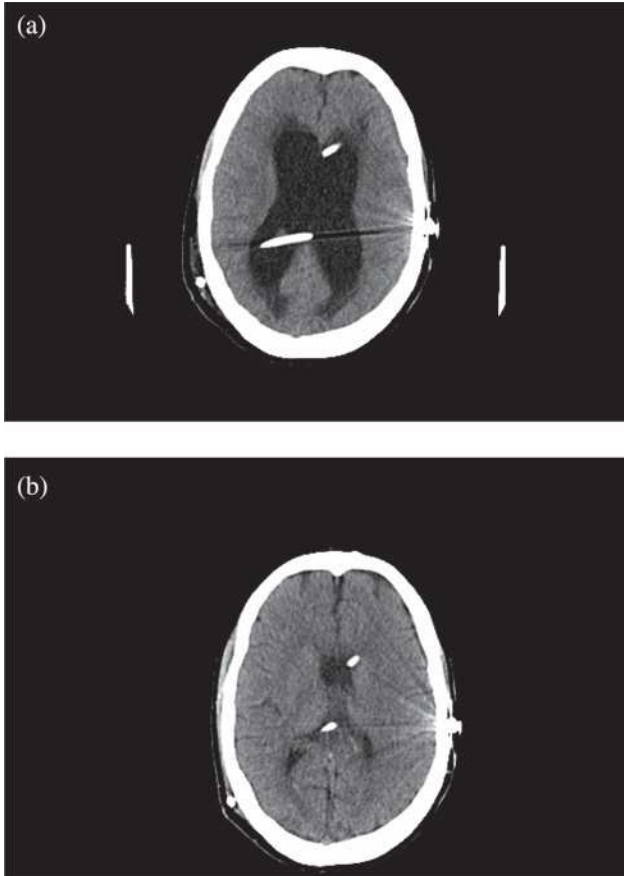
Axial CT scans of a young woman with multiple shunts *in situ*. She presented with a blocked shunt (Figure 1a). Note the presence of dilated ventricles as compared to the post-revision scan (Figure 1b)
